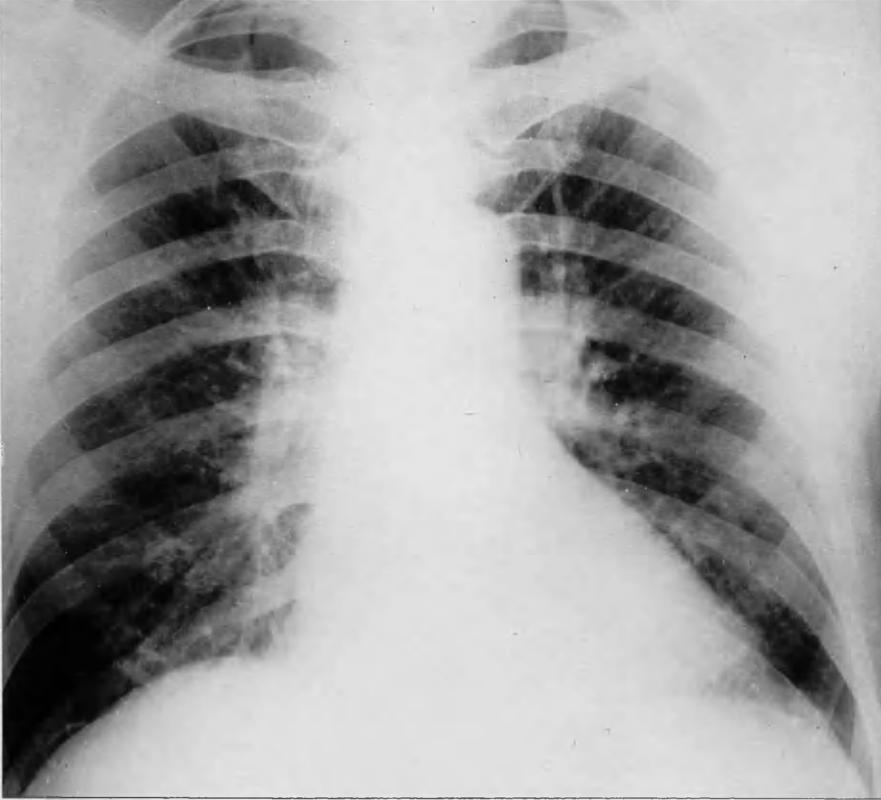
Chest X-ray in polycythaemia vera.
